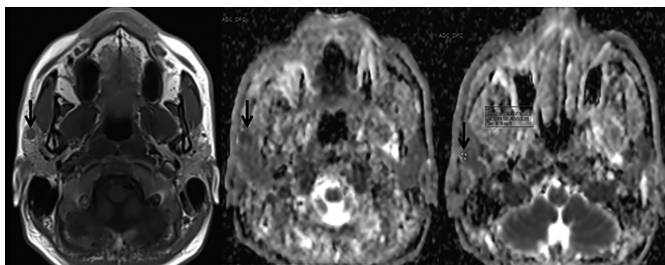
Measurement of the ADC value of the lymph node in the parotid gland in axial T1-weighted MRI by placing a region of interest on the ADC map.
